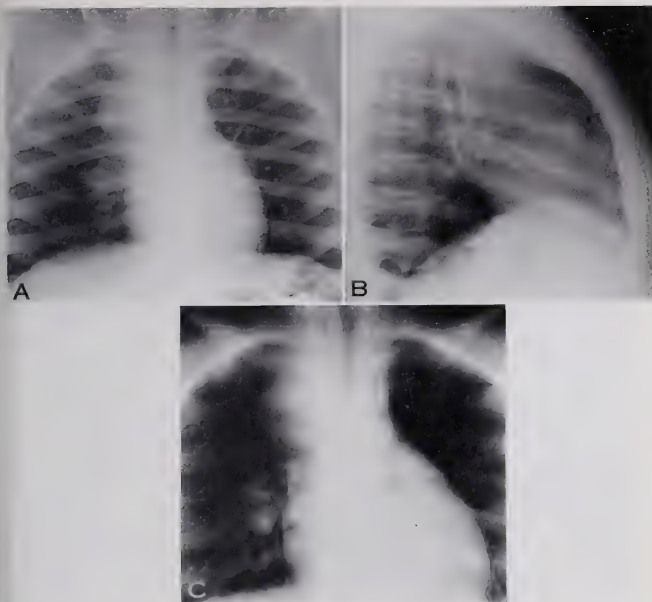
Initial chest roentgenogram demonstrates widening of the right paratracheal region. The tumor has an oval configuration and is sharply demarcated. The right hilum appears full suggesting minimal adenopathy in this region.
